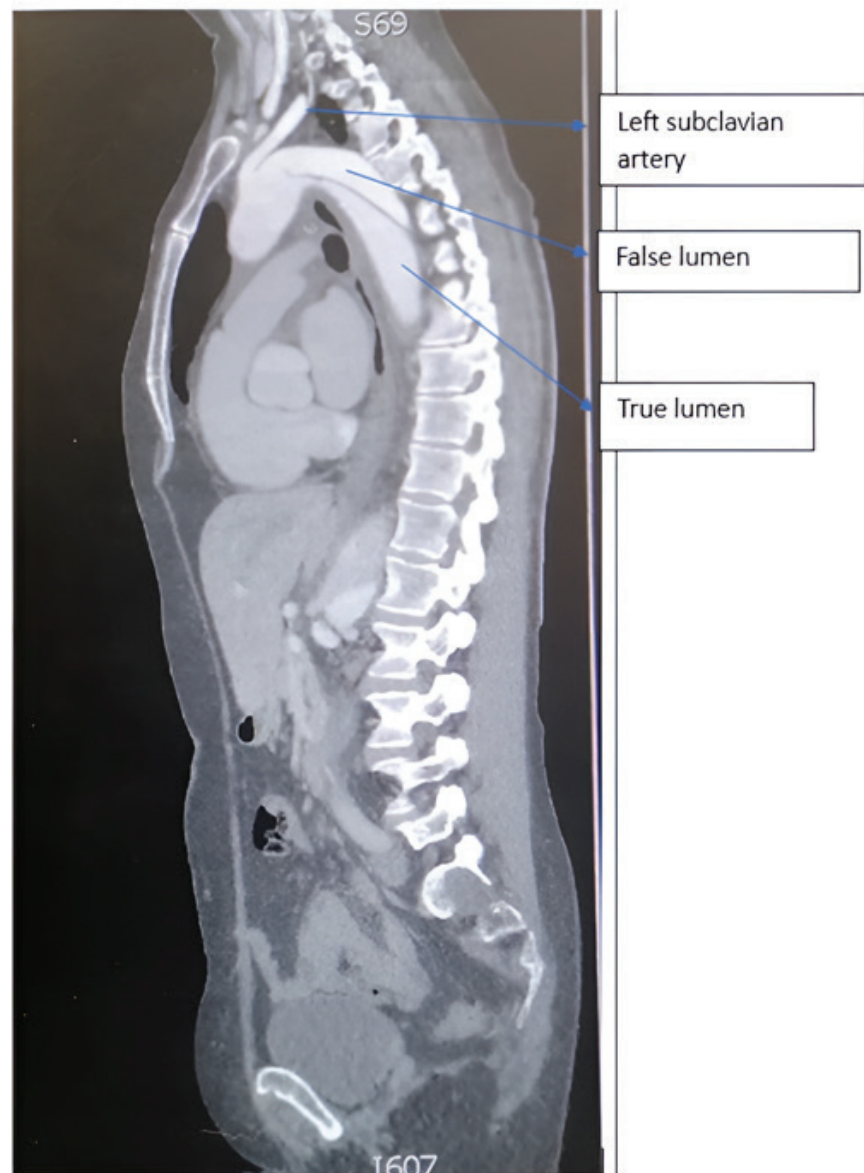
Computed tomography scan showing Type B acute aortic dissection (sagittal view).
